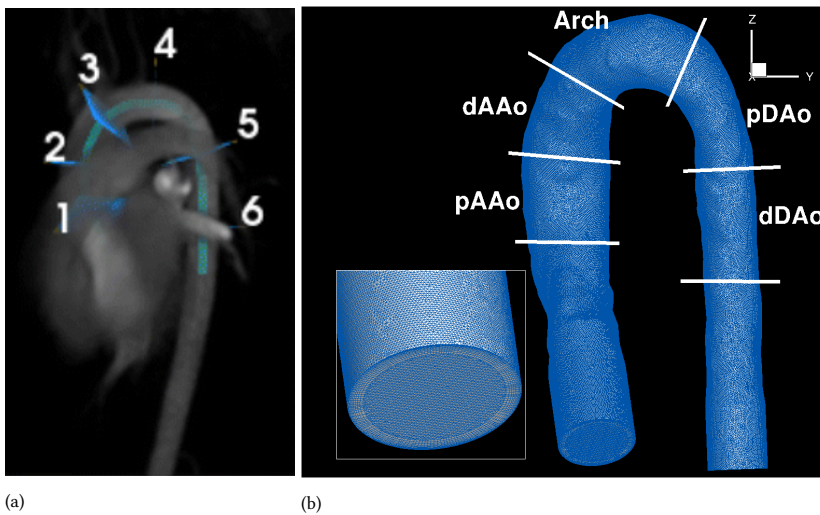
(a) Images obtained from MRI for volunteer 1 with visualized cut planes 1-6 and (b) pre-processed geometry with the smoothed surface, flow extension, and tetrahedral mesh with detail of fine boundary layer and the visualization of the analyzed significantly important regions of the thoracic aorta: pAAo - proximal ascending aorta, dAAo - distal ascending aorta, Arch - aortic arch, pDAo - the proximal descending aorta and dDAo - distal descending aorta (b)
